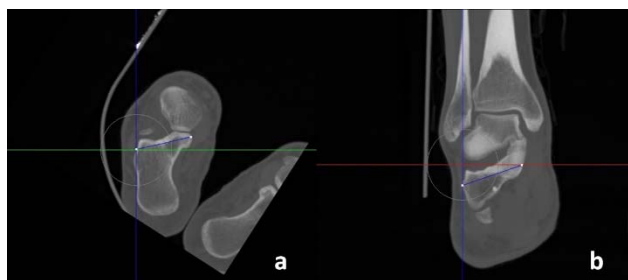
Distance between lateral wall and sustentaculum tali in axial plane CT (LSA) (a) Distance between lateral wall and sustentaculum tali in corone plane CT (LSC) (b)
